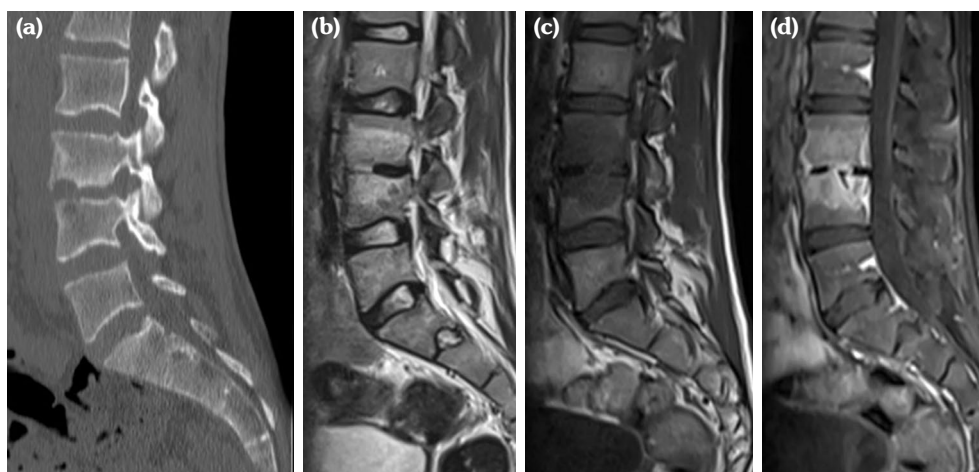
(a) Sagittal reconstructed computed tomography images show destructive lytic changes in end plates of L3 and L4 vertebral corpuses, and a modest loss of height accompanied by a decrease in disc space. (b) Sagittal T2 weighted (T2W) sequences show increased signal intensity, consistent with edema in affected vertebrae and intervertebral disc. (c) Sagittal T1W sequences prior to contrast enhancement show signal loss in vertebral corpuses. (d) Sagittal enhanced images show a diffuse contrast uptake in corresponding areas.
